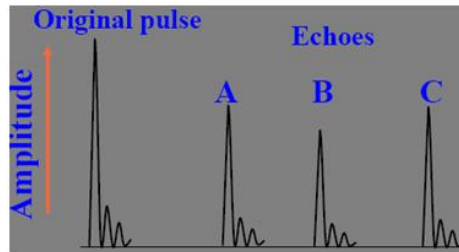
A-mode representation of backscatter ultrasound [86].
